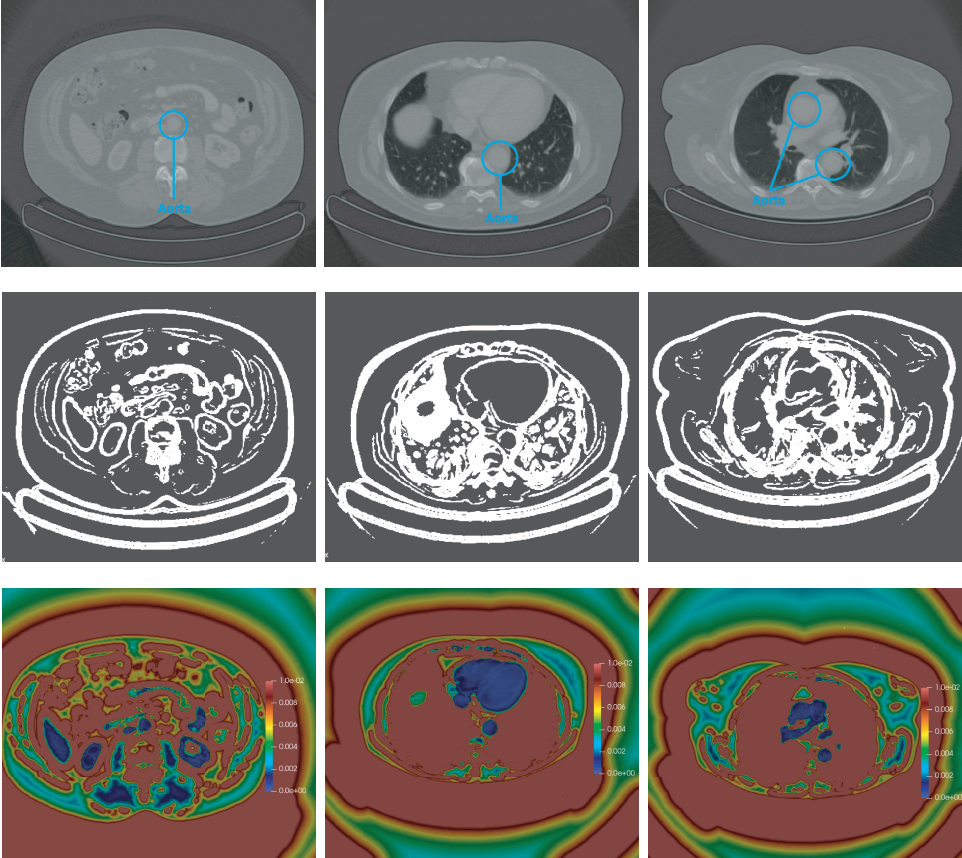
The first row shows three different axial views of the CT images where the aorta is visible (blue circles). The second row shows the edge image computed from the previous input slices. The third row shows the potential function corresponding to each slice. The slices are extracted from the 3D volume of Patient 1.
